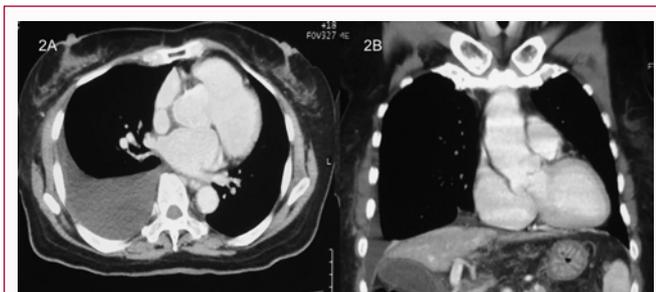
and 2B: Computed tomography of thorax showed right sided pleural effusion without any lung or mediastinal mass.
